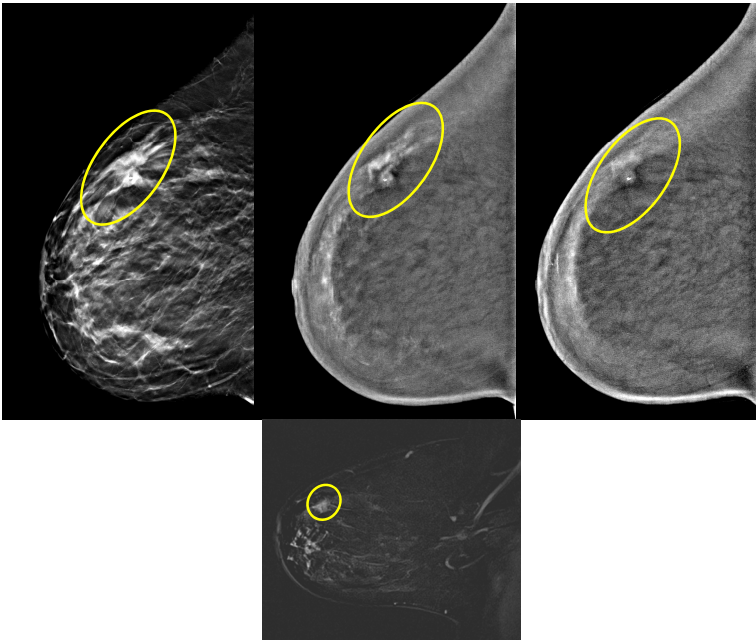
Invasive ductal carcinoma. Irregular enhancing mass in the upper breast, with washout kinetics. From left to right: Pre-contrast low energy DBT, Post-contrast DE subtraction at 20 s, Post-contrast DE subtraction at 3 m 25 s, and (bottom) subtraction MRI at 3 min.
